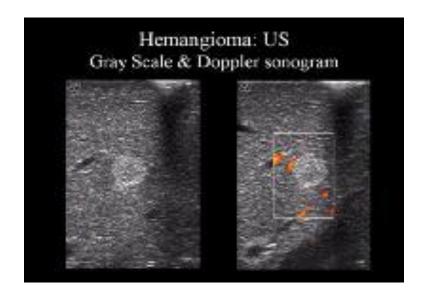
Gray-scale and Doppler ultrasonographic (US) images. These sonograms show a well-defined, uniformly hyperechoic liver mass with peripheral feeder vessels that are characteristic of a hemangioma.
